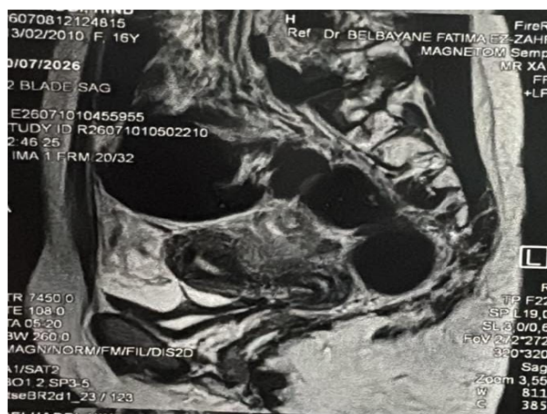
Sagittal pelvic magnetic resonance imaging demonstrating a complex cystic lesion in the pelvic/adnexal region consistent with a tubo-ovarian abscess.
